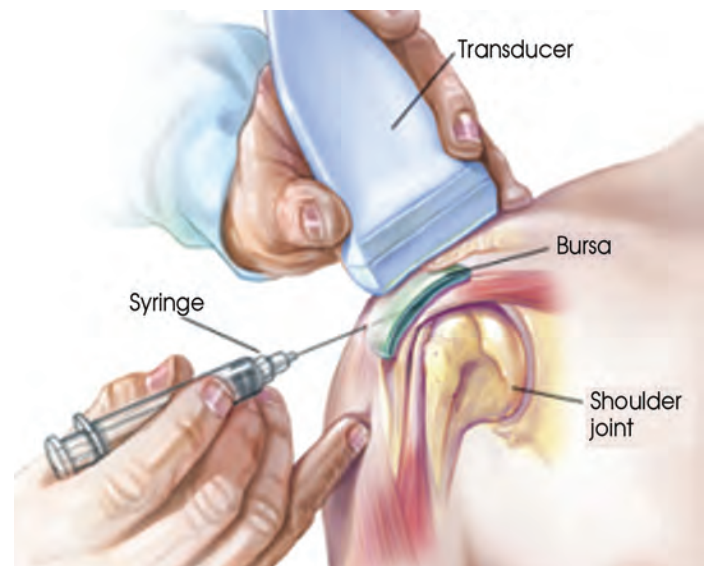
Ultrasound machines guide needle injections without harmful radiation exposure. Image courtesy of the Mayo Clinic.
